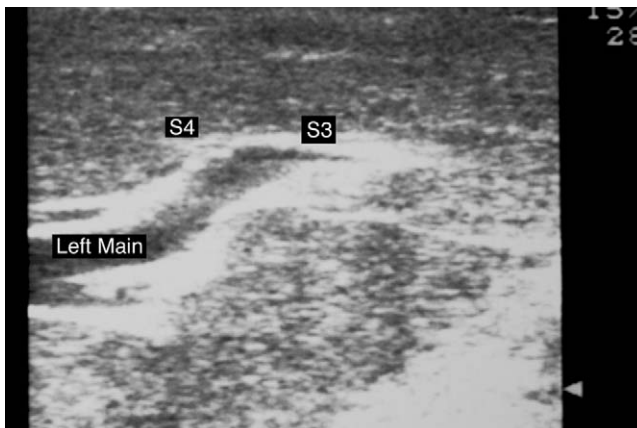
Ultrasonographic view of the left portal vessel (*left main*) and its branches to the Couinaud segments 3 (*S3*) and 4 (*S4*).
